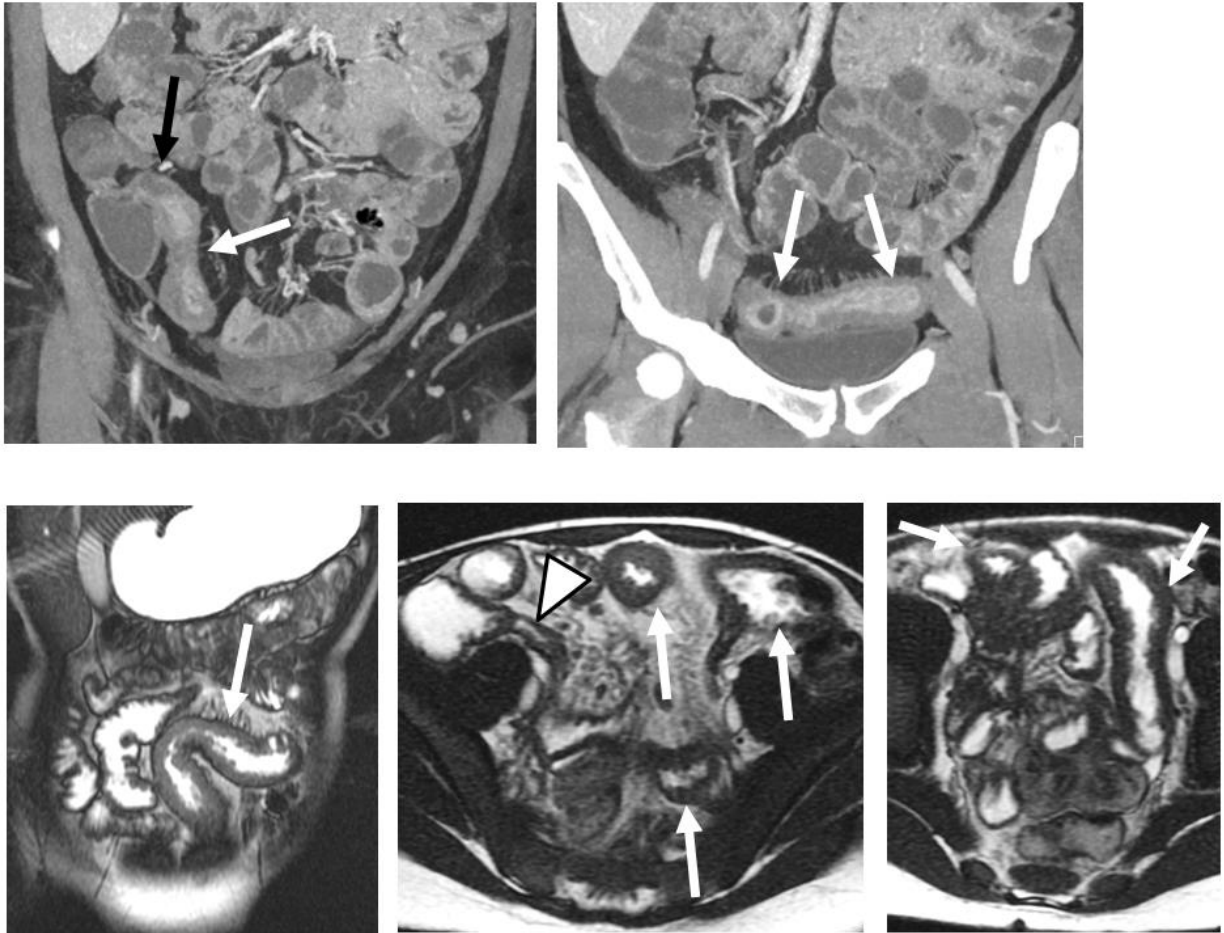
CT enterography performed two weeks after normal ileocolonoscopy show that the very distal terminal ileum (top left, black arrow) appears normal, but moderate to severe asymmetric inflammation indicating Crohn’s disease is present in the more proximal terminal ileum for approximately 20 cm (top row, white arrow). On bottom row in a different patient, MR enterography images demonstrate severe active small bowel inflammation (arrows) involving long segments of jejunum and ileum, but normal-appearing terminal ileum (arrowhead). Subsequent ileoscopy and biopsy were normal.
